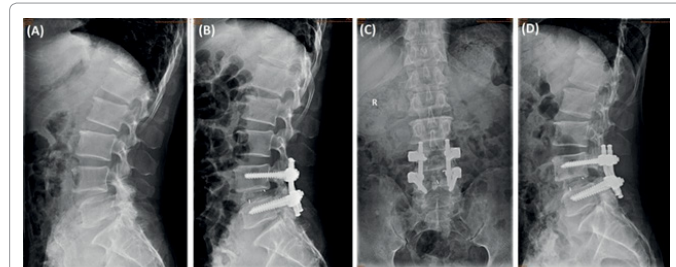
A 57-year-old woman with isthmic spondylolisthesis was surgically treated with PLIF *in situ*. (A) Preoperative lateral X-ray showed that slippage was 34.1% and focal lordosis was -3.0. (B) Immediate postoperative lateral X-ray showed that complete reduction of the spondylolisthesis (C) 9 month follow-up radiographs shows significant improvement in anterior vertebral height and kyphotic deformity (D) Final follow-up after 19 months of postoperative with complete reduction of the spondylolisthesis.
